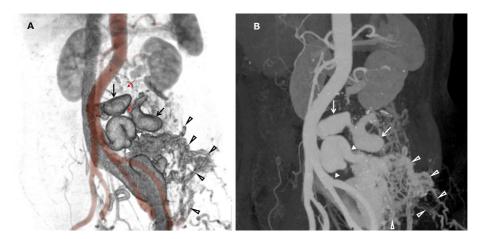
(A and B) Contrast-enhanced whole-body three-dimensional computed tomography images obtained at 70 years old at a previous hospital. The arrows indicated a lumbar aneurysm before impending rupture with a maximum diameter of 49 mm at the level of the second through the third lumbar vertebrae. The aneurysm was compressing the abdominal aorta to the right. The closed arrowheads indicate the developing dilatation of the median sacral artery. The open arrowheads indicate subcutaneous malformations of angiogenesis spread in the left sides of the lumbar, buttock, and thigh.
